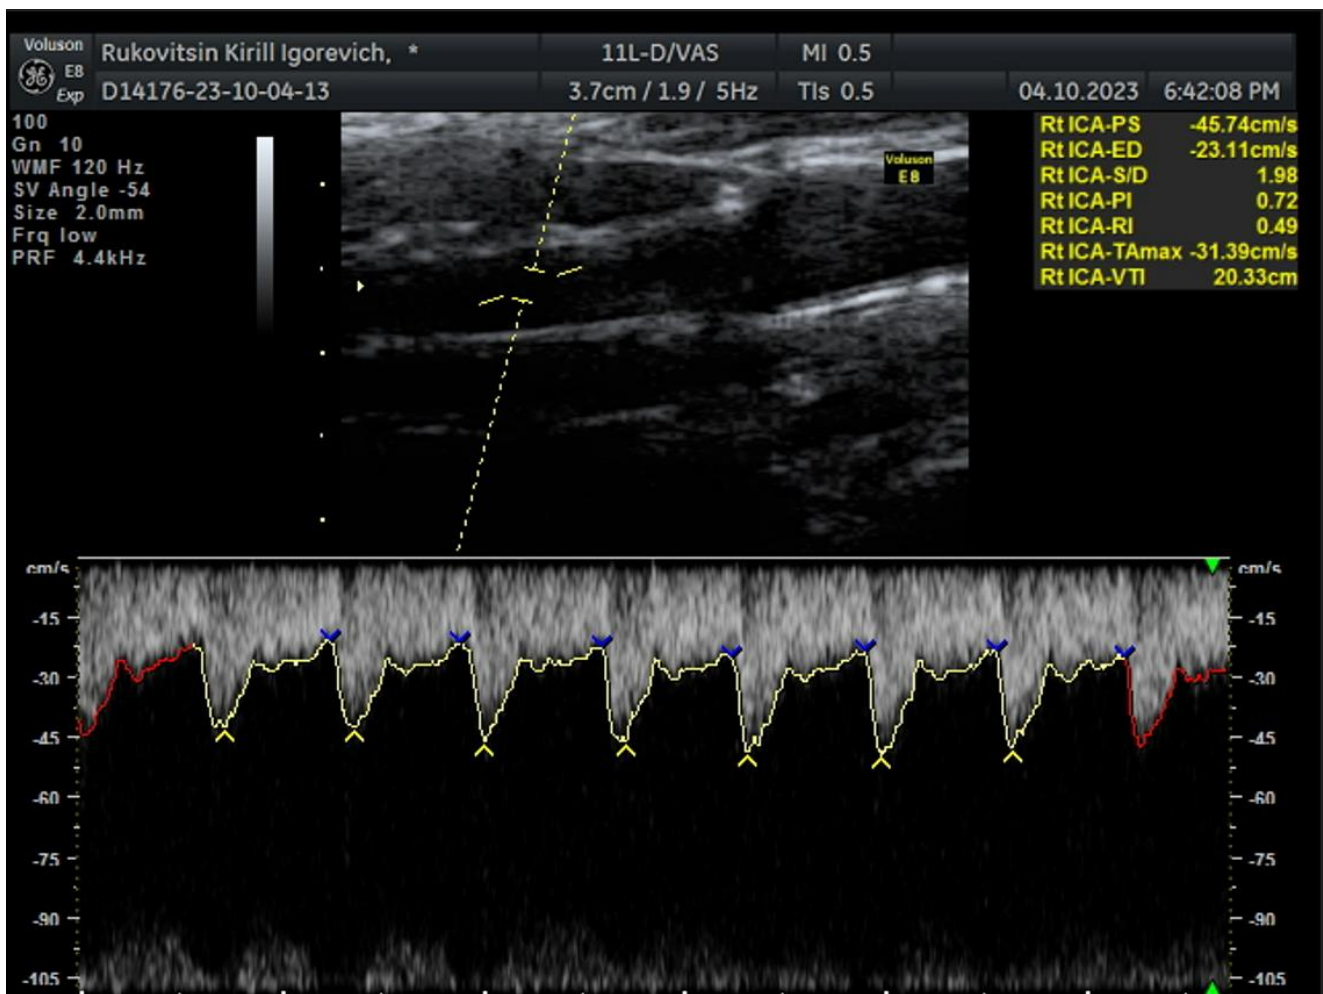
For the right ICA, we only have this suboptimal image. The waveforms are probably quite accurate, although the doppler angle correction is inaccurate. It is also overgained, and there is venous interference. That said, there is no delay in systolic upstroke, but some increased acceleration of beginning of diastole is seen (raised pulsatility). The best place to measure this is usually 1-2 cm distal to the carotid bulb, but in this case we are at the distal ICA.
